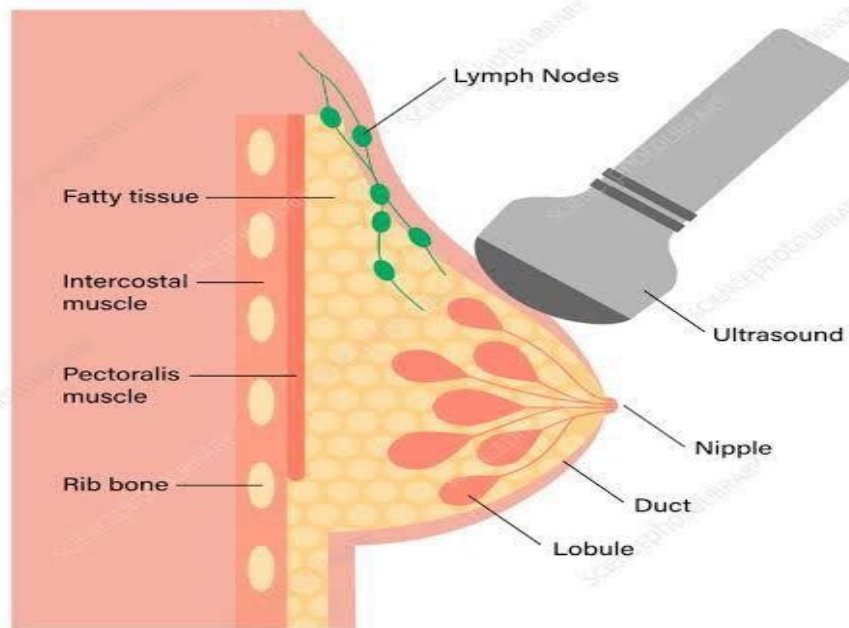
Detection of breast cancer by Ultrasonography
